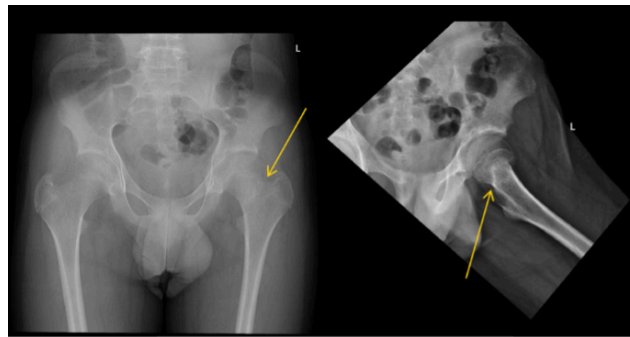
Bilateral hip X-ray with mildly impacted left femoral neck fracture (yellow arrow).
